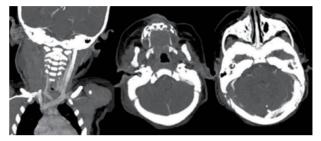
Contrast-enhanced computed tomography scan of the head and neck (coronal and axial maximum intensity projection reformatted images) showing no enhancement of the right internal jugular vein, sigmoid and transverse sinuses, consistent with thrombosis.
